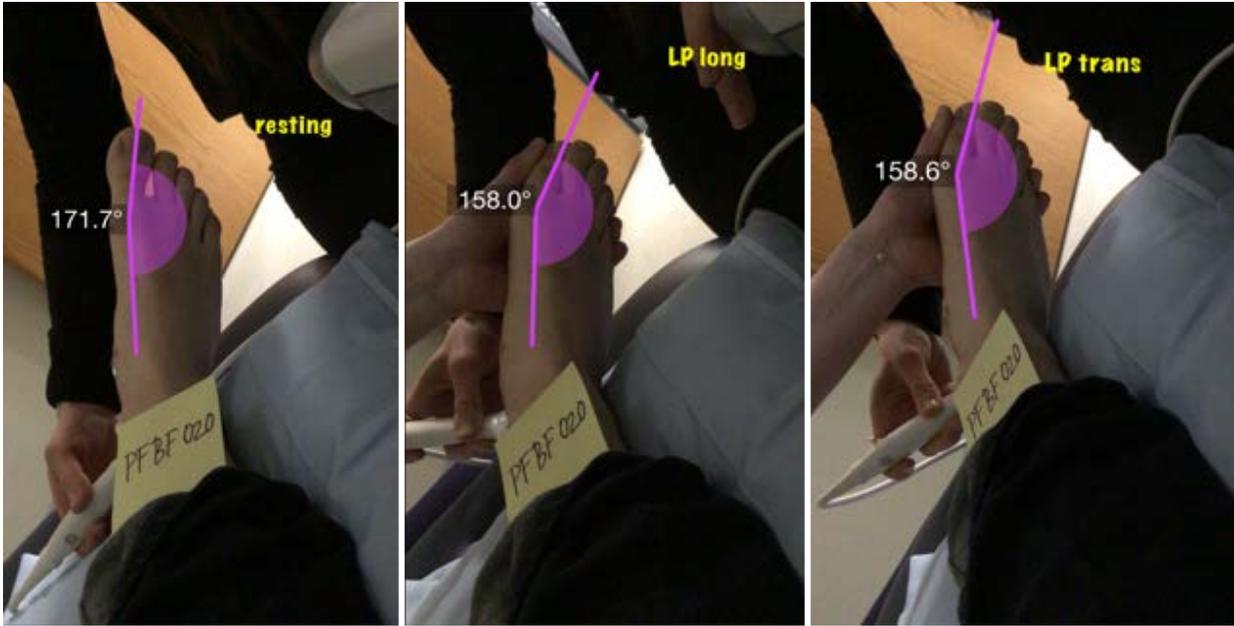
Photographs of each subject's foot were taken at rest (left photo) and during both of the adducted hallux phases (center and right photos) of the ultrasound protocol. First metatarsophalangeal joint angles were then measured using Dartfish software.
